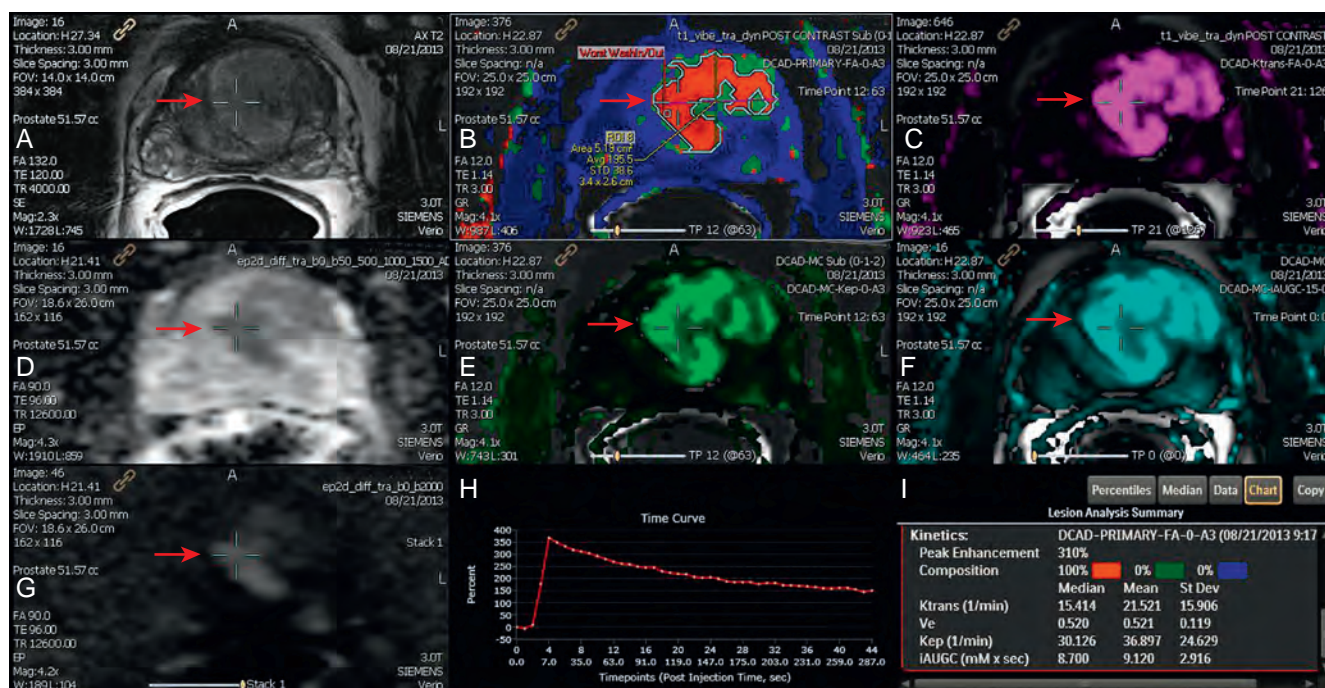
A 65-year-old man with a prostate-specific antigen of 38.9 and 16 prior negative biopsies with magnetic resonance (MR) ultrasound fusion biopsy proven Gleason 4 + 4 prostate cancer. A, T2-weighted image with an anterior lesion within the central gland, 3.5 cm × 2.7 cm × 3.5 cm (red arrow). B and H, Dynamic contrast enhanced MRI (DCE-MRI) with color mapping exhibiting a focal type 3 enhancement curve. C, Elevated K^{trans} (transfer constant). D, Apparent diffusion coefficient map with low signal. E, Elevated K^{ep} (rate constant). F, Area under the curve. G, B-2000 diffusion-weighted sequence with an area of high signal intensity. I, Quantitative summary of the large anterior central gland lesion.
